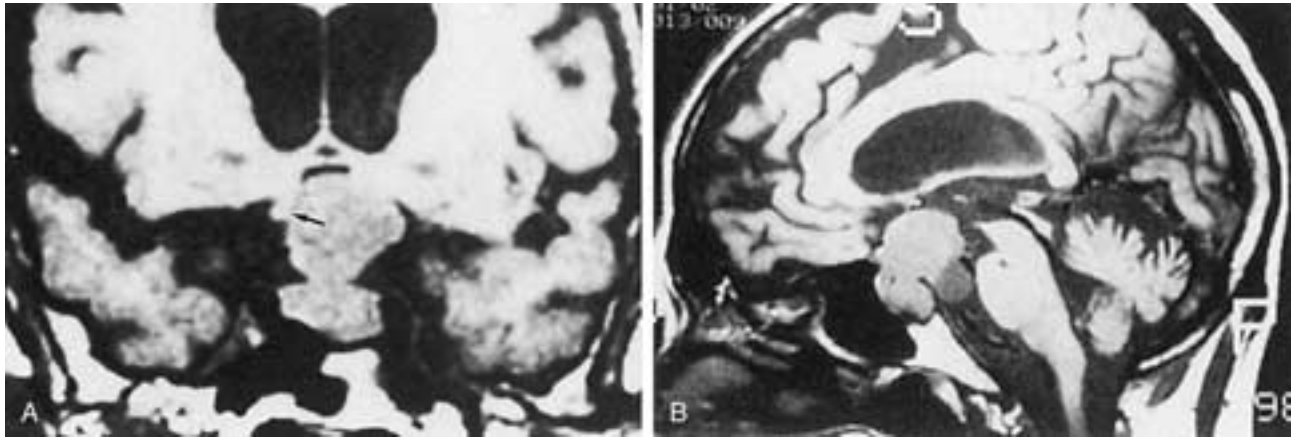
Pituitary adenoma with chiasmal compression in a 70-year-old male with bitemporal hemianopsia. A, Coronal T1-weighted image shows an isointense mass within the sella, expanding it to the left and extending through the diaphragma sella (site of the waist) into the suprasellar cistern. Note the compression of the right optic nerve (arrow). B, Sagittal T1-weighted image shows an intrasellar tumor mass. The optic chiasm is not distinguishable in this view.
